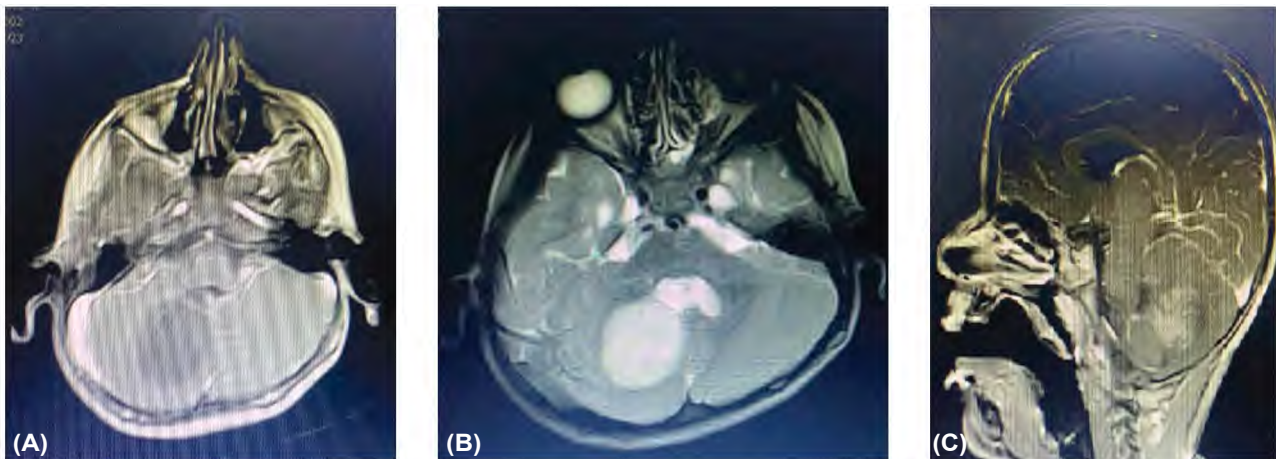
A 3-year-old female child who presented with right-sided ataxia: (A) Axial T1WI brain MRI without contrast, (B) Axial T2WI, and (C) Sagittal T1WI with contrast showing a right cerebellar well-circumscribed complex cystic pilocytic astrocytoma (3.1x3.0 cm). The tumor displays low signal intensity in the axial T1WI, bright signal intensity in the axial T2WI with inhomogeneous enhancement of the intracystic solid component within in the post contrast sagittal T1WI.
